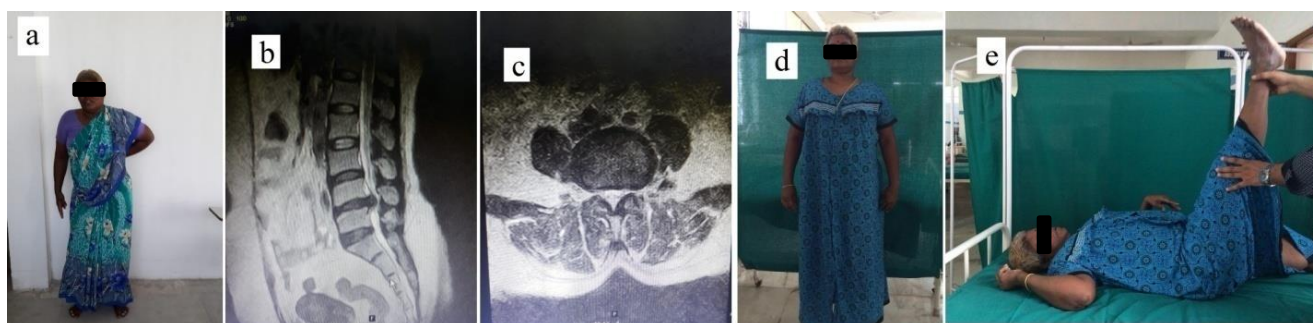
(A) Preoperative sciatic list due to nerve root irritation; (B and C) MRI sagittal and axial T2W images of L4-L5 disc prolapsed; (D and E) postoperative pictures showing disappearance of sciatic list and negative SLRT following fenestration discectomy.
